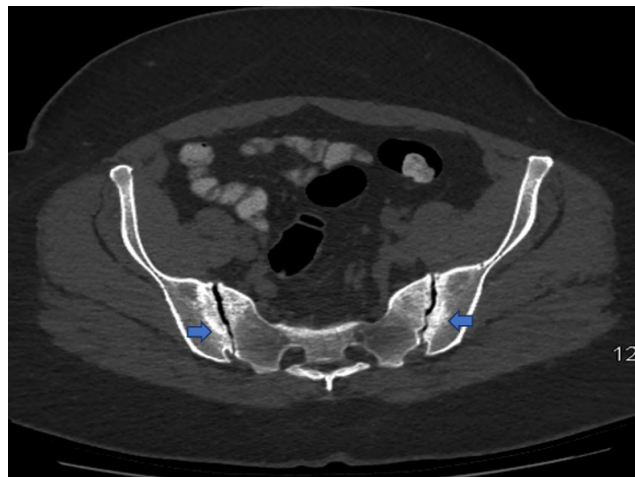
Axial CT scan showing sclerosis of iliac bones (arrows) adjacent to sacroiliac joints with sparing of the joint for any erosions.
